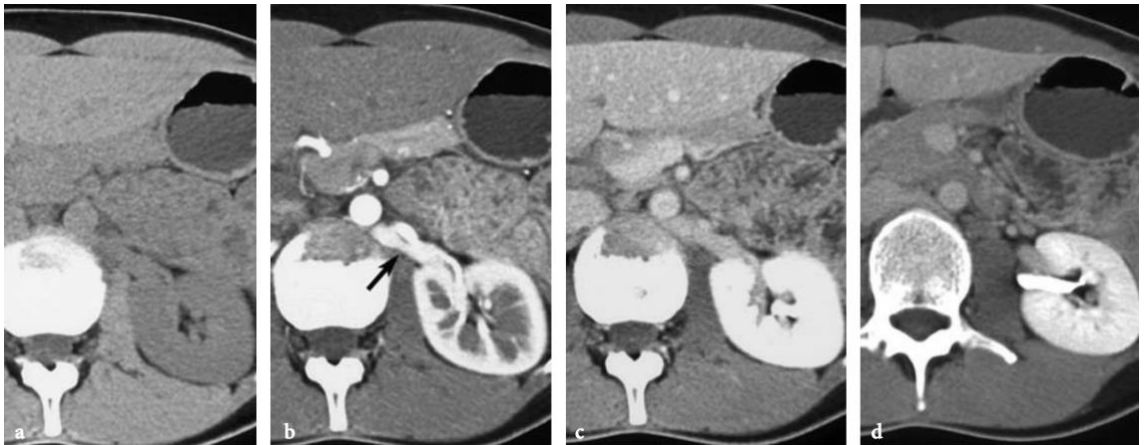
Different phases of renal enhancement at CT images of the same tissue. (a) Precontrast CT scan. (b) AP scan. The arrow indicates its good opacification of the retro-aortic renal vein. (c) VP scan. (d) EP scan.
